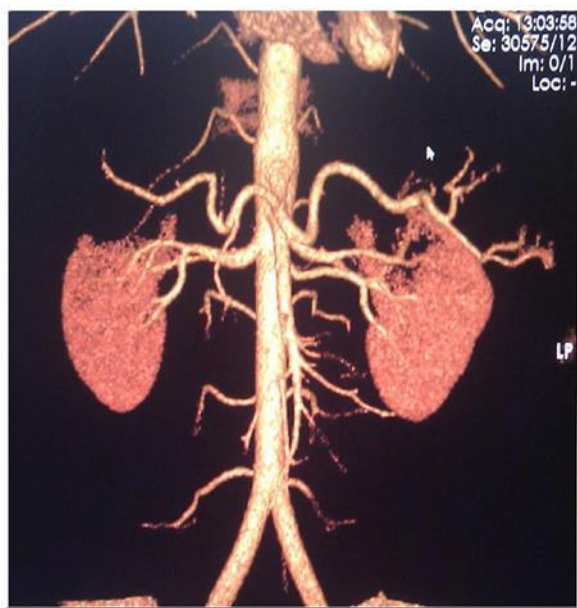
Volume rendering CTA image showing left accessory artery. Bone removal application was bone.
